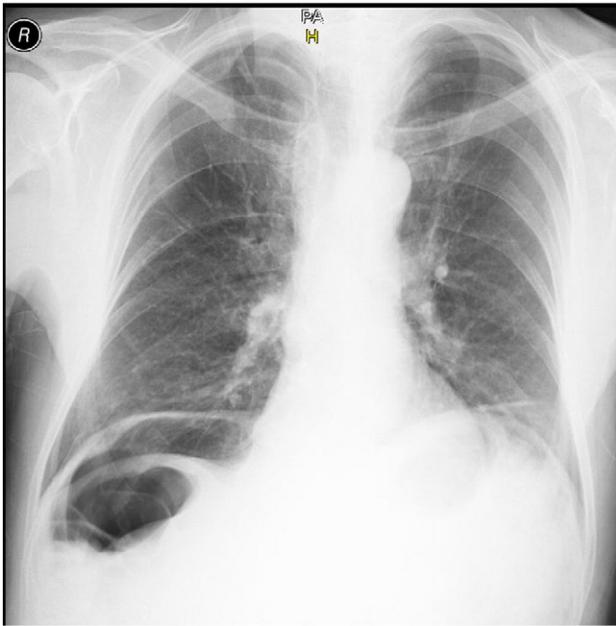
A posteroanterior chest radiograph revealed an elevation of the right part of the diaphragm with abdominal gas interposition between the liver and the diaphragm.
